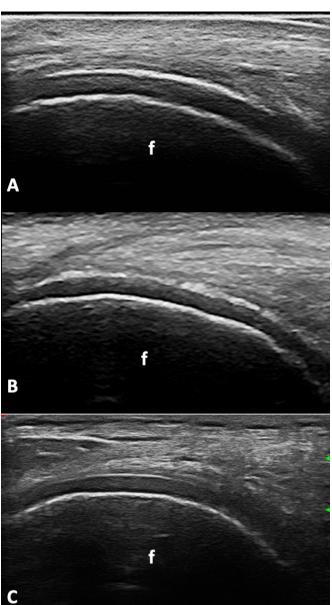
US findings fulfilling the OMERACT definition for DC sign in gout (A) and CPPD disease (B).Panel C shows the normal US appearance of the hyaline cartilage. Dorsal longitudinal scans of the femoral condyles' hyaline cartilage acquired with the knee in full flexion. CPPD, calcium pyrophosphate deposition; DC, double contour sign; f, femur; OMERACT, Outcome Measures in Rheumatology; US, ultrasound.
